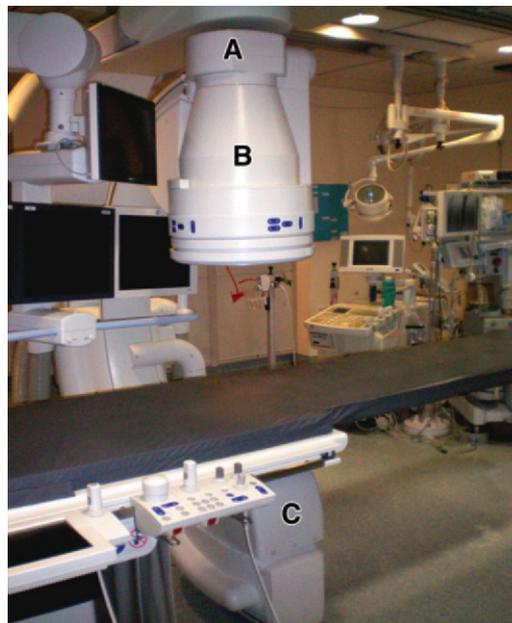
Photograph of an angiography room shows a fluoroscopy system with an image intensifier (B) (field of view [FOV], 40 cm) and television camera (A). C = x-ray tube.
